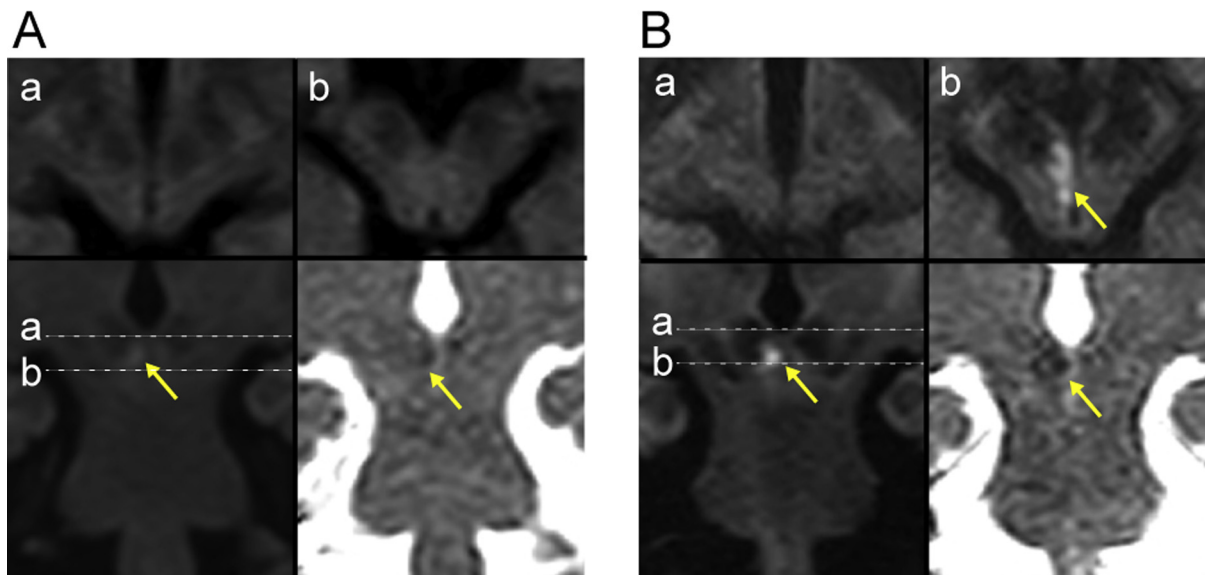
An acute ischemic lesion in the right para-median midbrain with restricted diffusion on diffusion-weighted imaging (DWI) and apparent diffusion coefficient (ADC) map. Yellow arrows indicate the lesion (upper figures: axial images, each corresponding to the axial section indicated by the dotted line in the lower left-hand side figure. Lower figures: coronal images; left, DWI; right, ADC map). (A) On admission, no definite lesion was detected on axial DWI; however, coronal DWI depicted a slightly hyperintense area suggestive of acute ischemic lesion in the midbrain. The coronal ADC map also showed a slightly hypointense area. Note that the lesion is located between the axial sections. (B) Two days later, the lesion became more evident even though no neurological signs progressed during the 2 day period. The lesion is also depicted on axial DWI.
